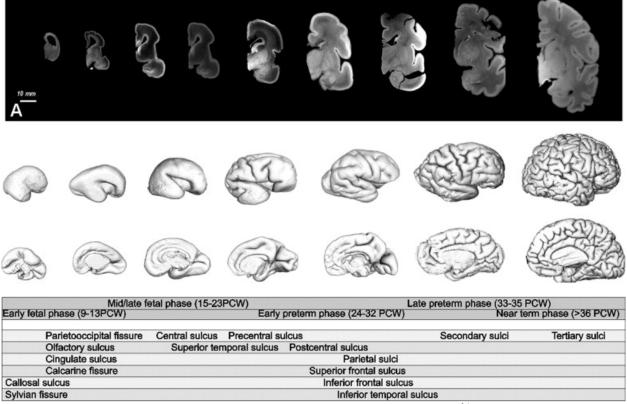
The developing foetal brain from 9-40 postconceptional weeks ³⁴ Reprinted from Semin Perinatol 2009; 33: 220-33. Kostovic I, Vasung L. Insights from in vitro fetal magnetic resonance imaging of cerebral development. Copyright (2022), with permission from Elsevier
